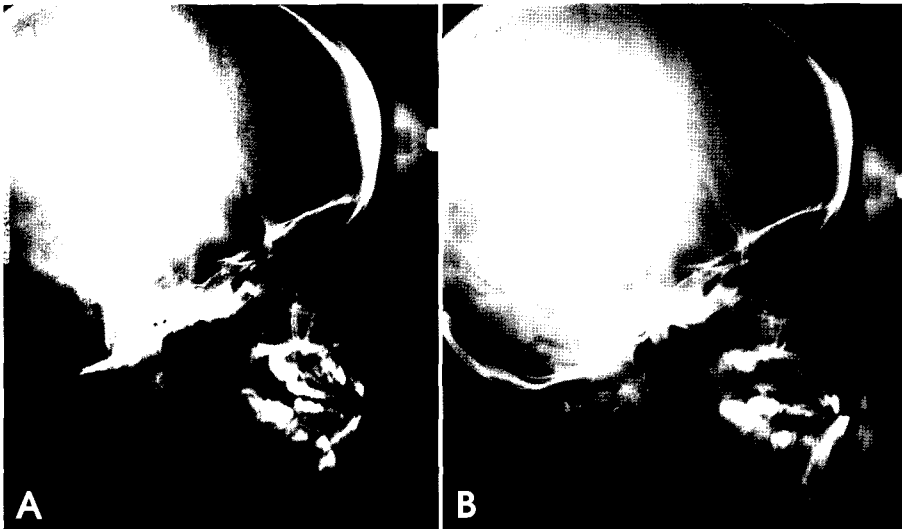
Lateral cephalometric radiographs of at age 6 (A) and 10 (B) showing maxillary hypoplasia and facial disproportion.
